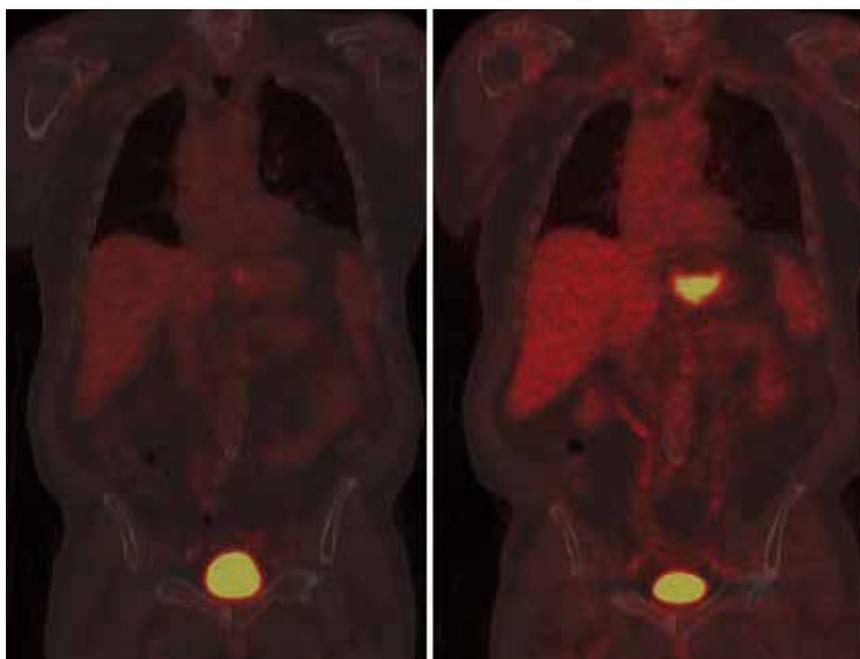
Registration of PET and CT imaging provides combined anatomic and physiologic information. Uptake values are relative and uptake in normal tissues (such as liver) provides a reference.
